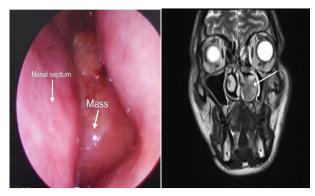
A: Diagnostic Nasal Endoscopy showing left nasal mass. B: CE MRI coronal section showing left nasal mass with indentation onto medial wall of left maxillary sinus.
